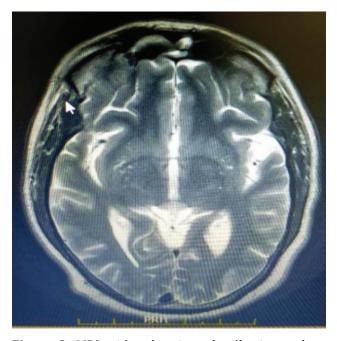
MRI with subperiosteal collection and an intracranial involvement.
